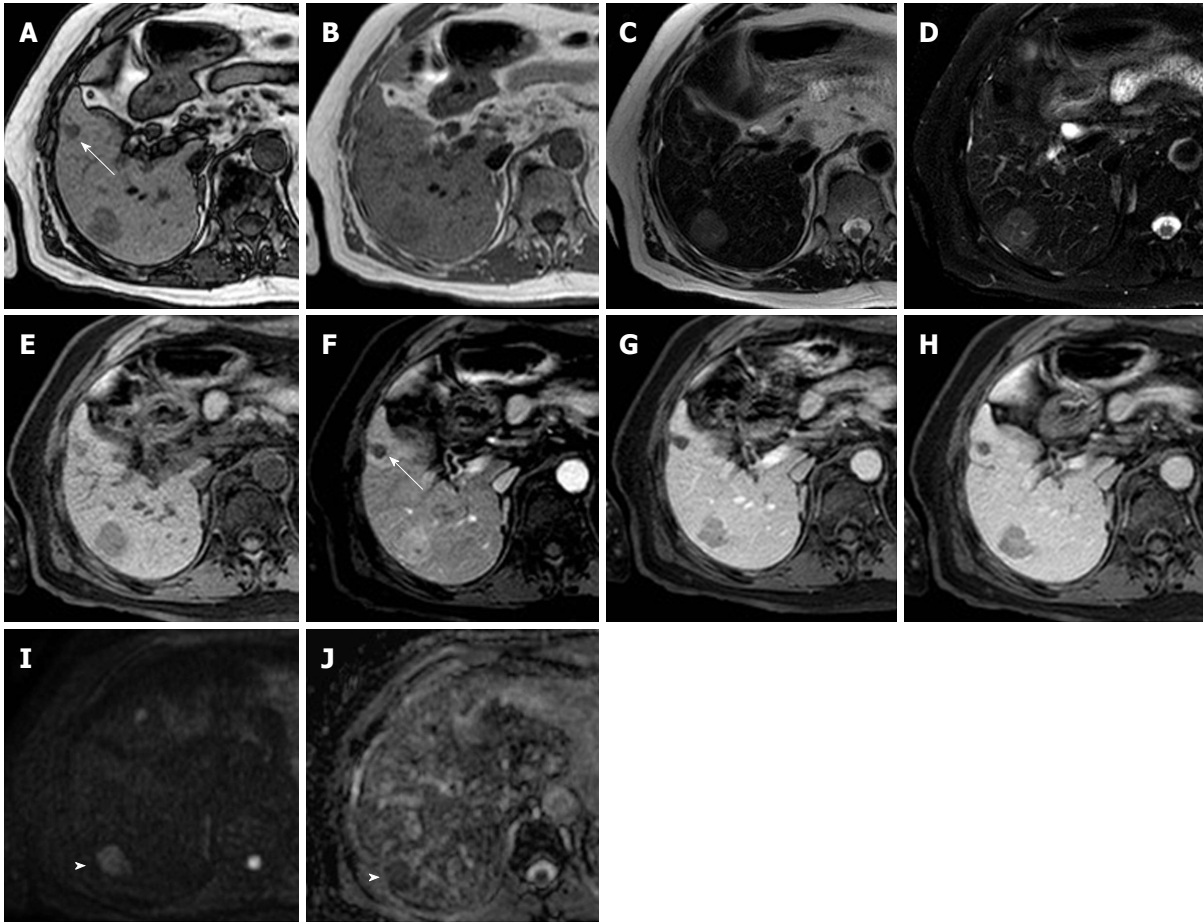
Gd-EOB-DTPA enhanced magnetic resonance images of a 61-year-old patient with hepatocellular carcinoma nodule in the VII segment of the liver. Panels A-B: A single nodule slightly hypointense on the T1-weighted “in phase” sequence (A) with a signal drop in the “out of phase” sequence, as per fat deposition. Panels C-D: On T2-weighted image without and with fat saturation the nodule appears slightly hyperintense. Panels E-H: Dynamic contrast-enhanced images demonstrate the typical contrast behavior of hepatocellular carcinoma: Which appear hypervascular during the arterial phase (F) with wash-out in portal and delayed phase (G-H). Panel I-J: Diffusion weighted image (DWI) shows the hyperintense pattern of the lesion which appear hypointense on the relative apparent diffusion coefficient map (arrowhead). Previously treated lesion with transarterial chemoembolization is recognizable, in panel A-E-F-G-H, at V segment of the liver (arrow). No any restriction of signal intensity is evident on DWI (panel I-J).
